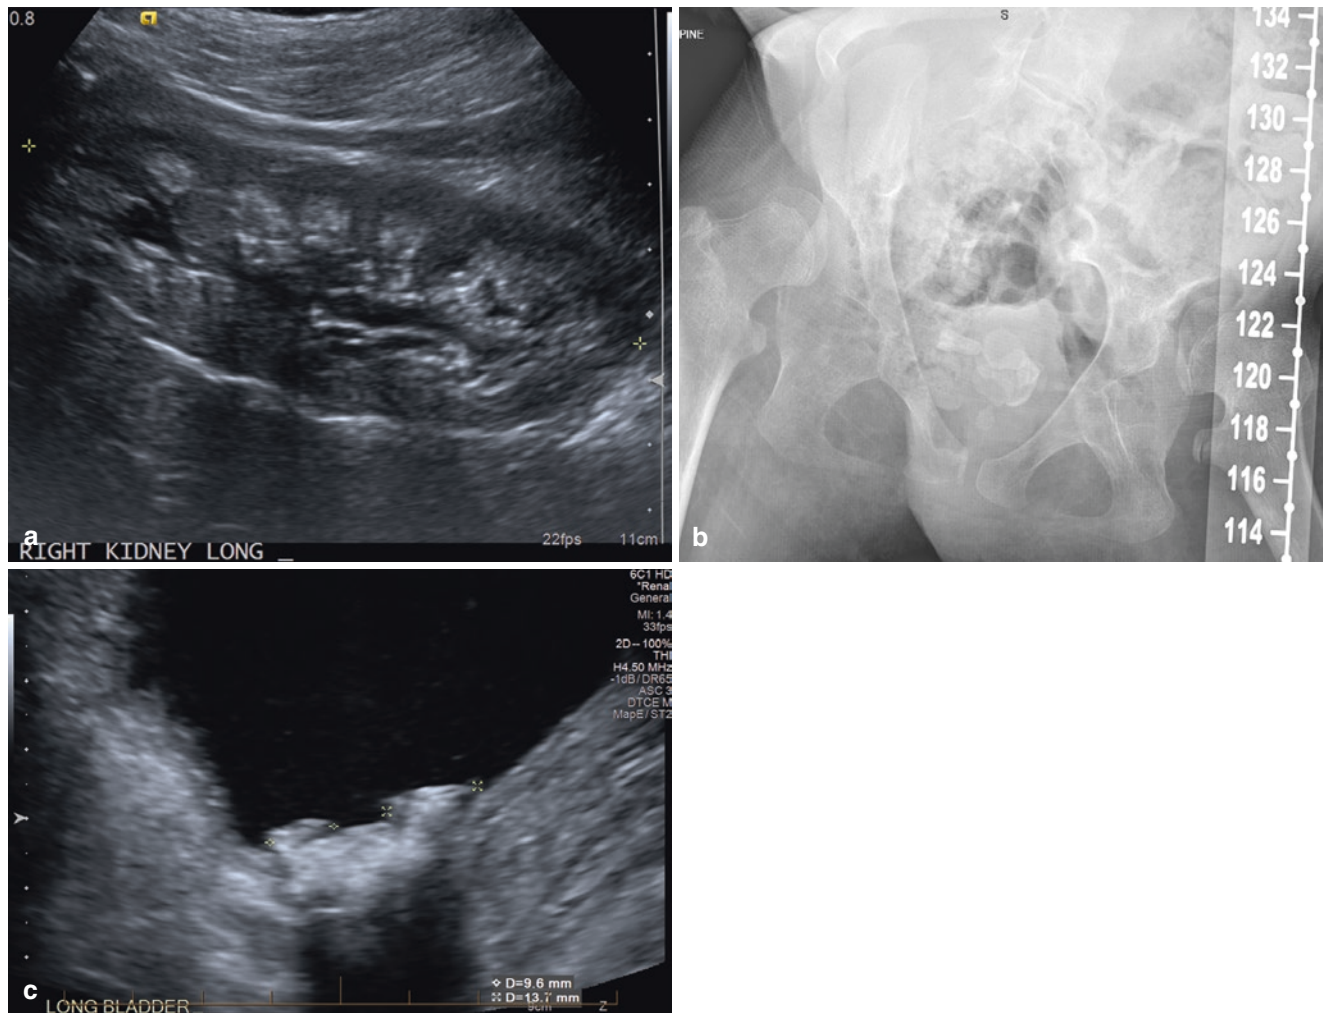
(a) Longitudinal ultrasound image of the right kidney in a patient with nephrocalcinosis due to hypercalcaemia. The renal pyramids are markedly hyperechoic relative to the cortex. (b) X-ray of the pelvis in a patient with bladder calculi. The calculi are visible as large
